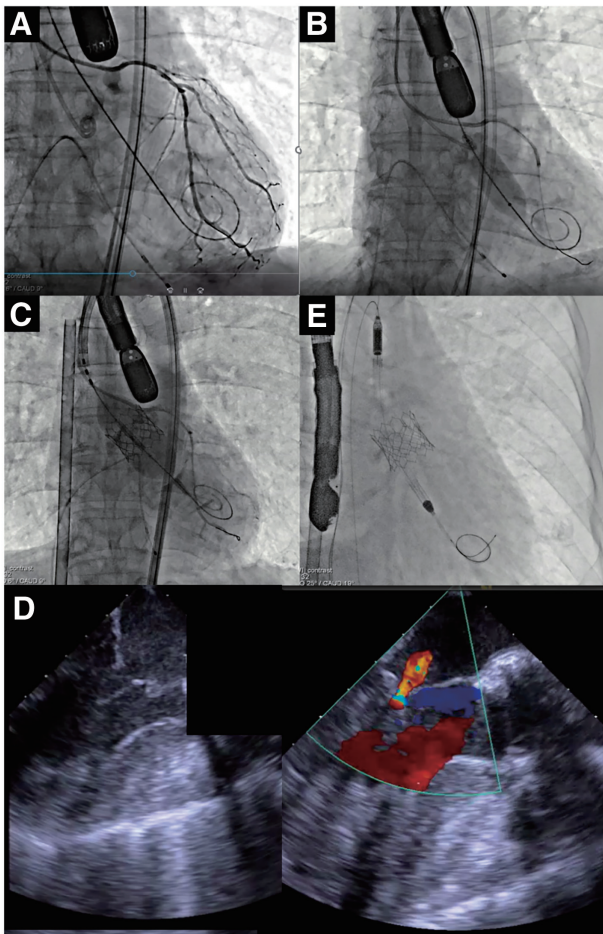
Procedural findings. (A) The procedure was performed to protect the left coronary artery, which was identified as low. The initial placement of the guidewire was in the anterior descending artery. However, due to its subsequent extrusion, the protection was modified to the circumflex artery. (B) Balloon aortic valvuloplasty was attempted under rapid pacing; however, slippage occurred, and sufficient expansion could not be achieved. (C) The transcatheter aortic valve implantation procedure was continued, and a Sapien 3 Ultra Resilia 26-mm valve was implanted. (D) Transesophageal echocardiography revealed separation of the anterior and posterior mitral leaflets (A2/P2). (E) Subsequently, the Impella CP was implanted
